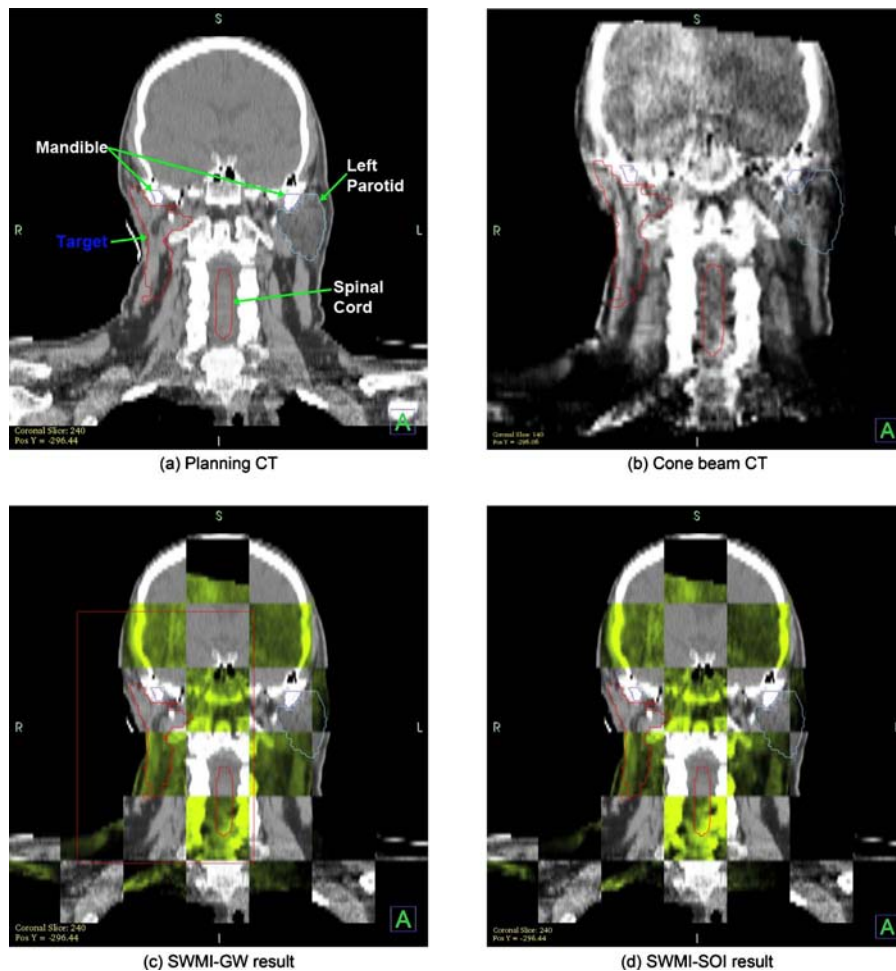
Image registration result for a head and neck image set. (a) Planning CT image with the ROI overlaid. (b) A cone beam CT of 28th day after the planning CT is taken. (c) The registration result of SWMI-GW with the weight centered at beam isocenter. The rectangular box shows the $\pm 2\sigma$ boundary for SWMI-GW registration. (d) The result of SWMI-SOI registration.
